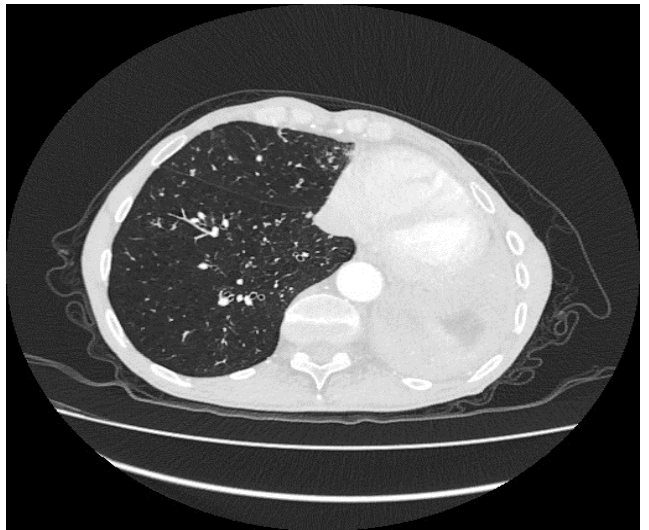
Patient I (chest CT scan).
